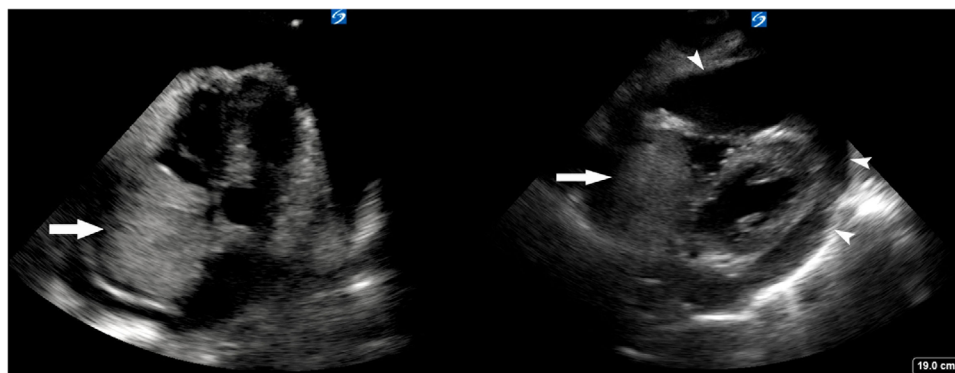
Apical -chamber (left panel) and parasternal long axis (right panel) views of the heart using point-of-care ultrasound showing a right atrial mass (arrow) with pericardial effusion (arrowheads)
